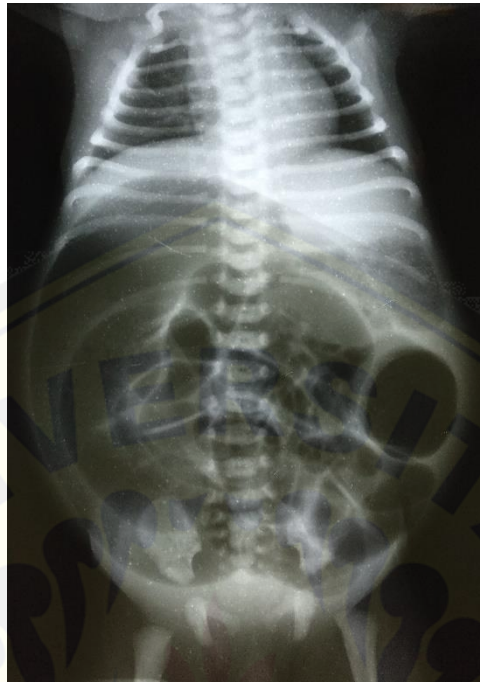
Abnominal X-Ray show distended bowel and air fluid level
